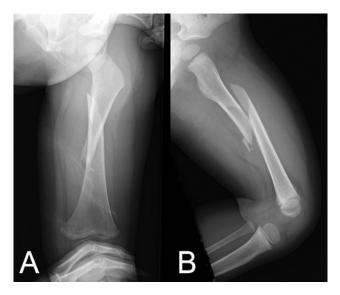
(A) Anteroposterior and (B) lateral radiograph of the left femur of a 2-year-old male showing a spiral mid-diaphyseal femur fracture.
